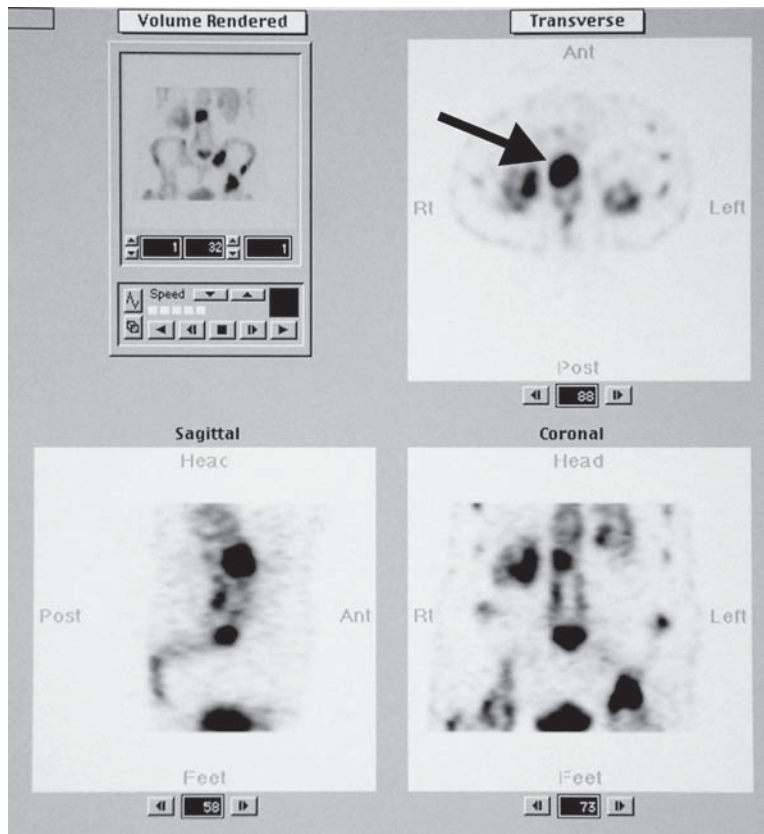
Metastatic lung cancer. The volume rendered SPECT image (upper left) shows metastases to the spine and pelvis. The transverse image (upper right) shows involvement of the vertebral body and right pedicle (*arrow*).
